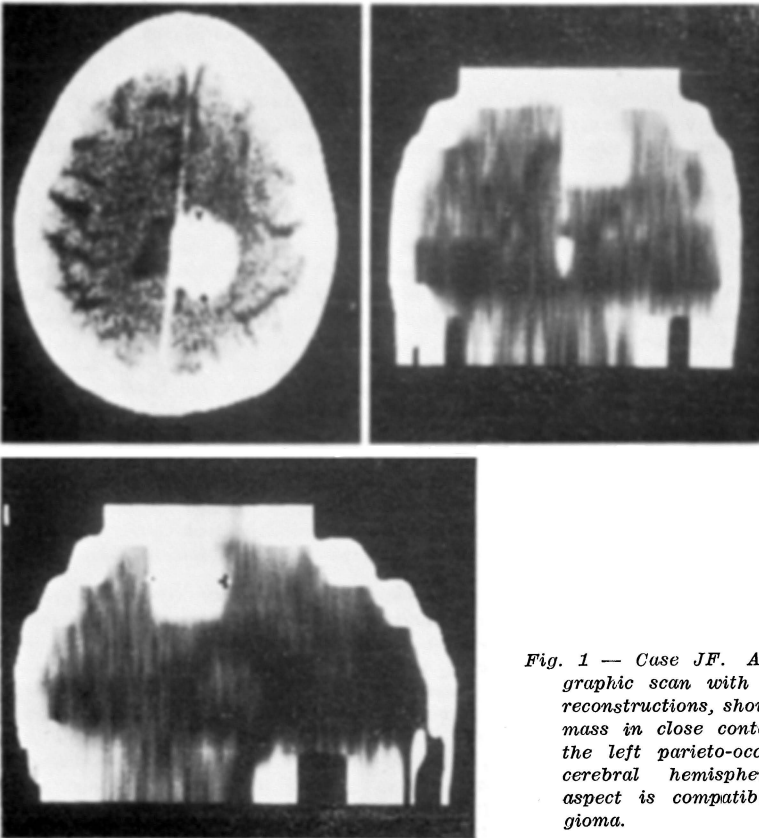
Case JF. Axial computed tomographic scan with coronal and sagittal reconstructions, showing round enhancing mass in close contact with the falx in the left parieto-occipital region of the cerebral hemisphere. The radiologic aspect is compatible with falx meningioma.
